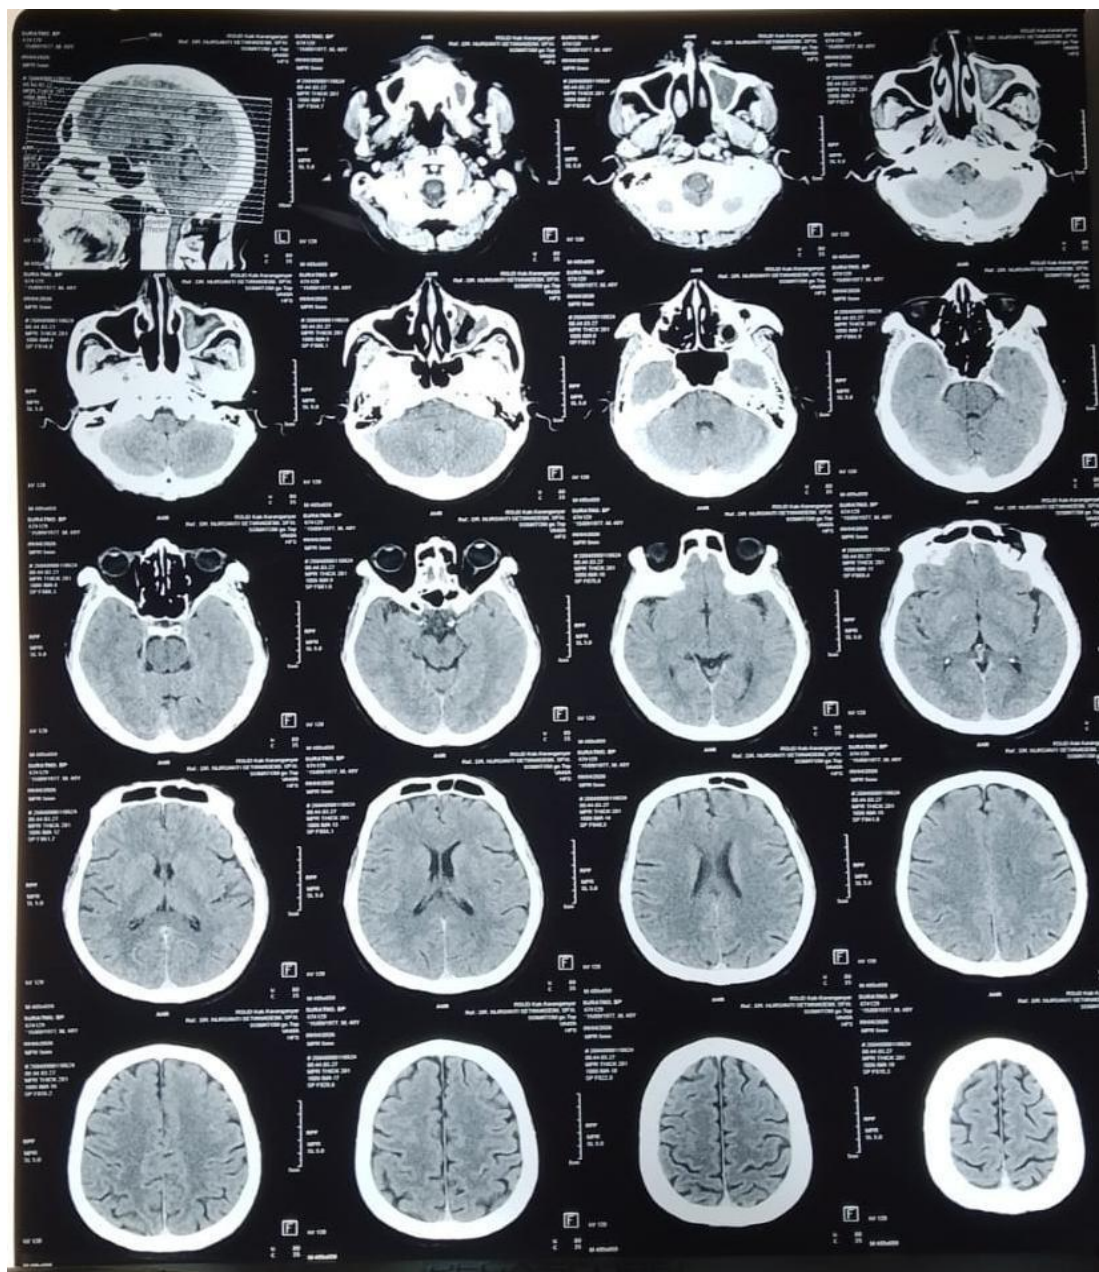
CT Scan Findings
